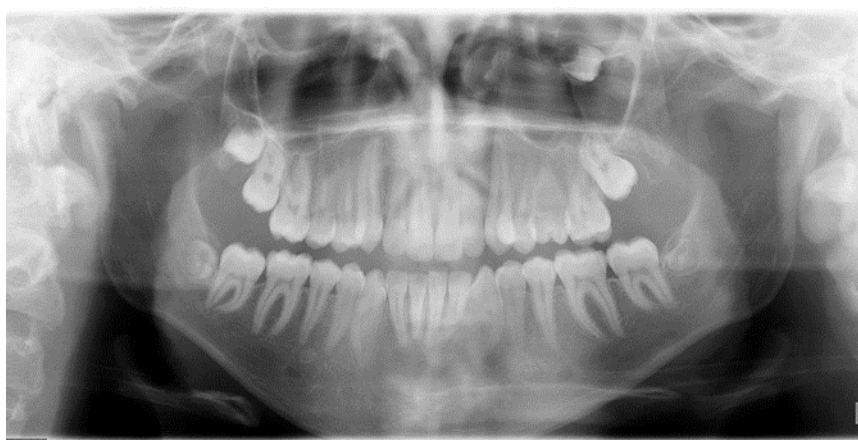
Patient initial Panoramic x-ray.
